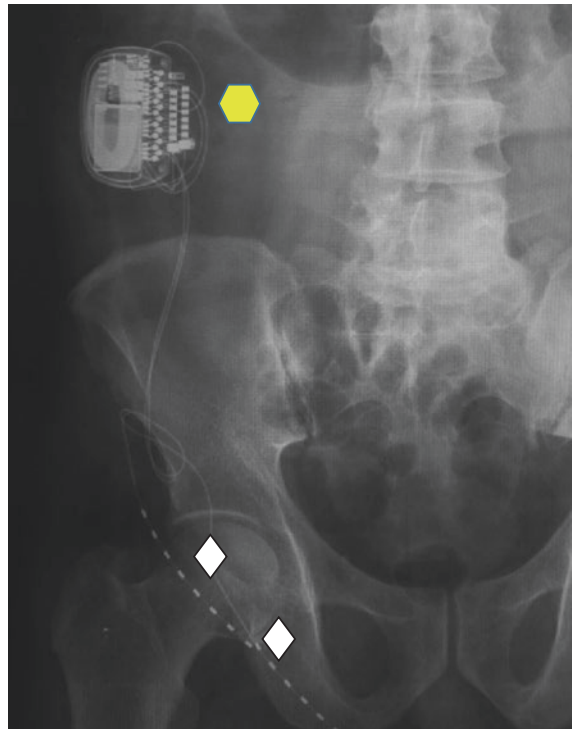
X-rays of implanted peripheral nerve stimulation systems for inguinal pain
